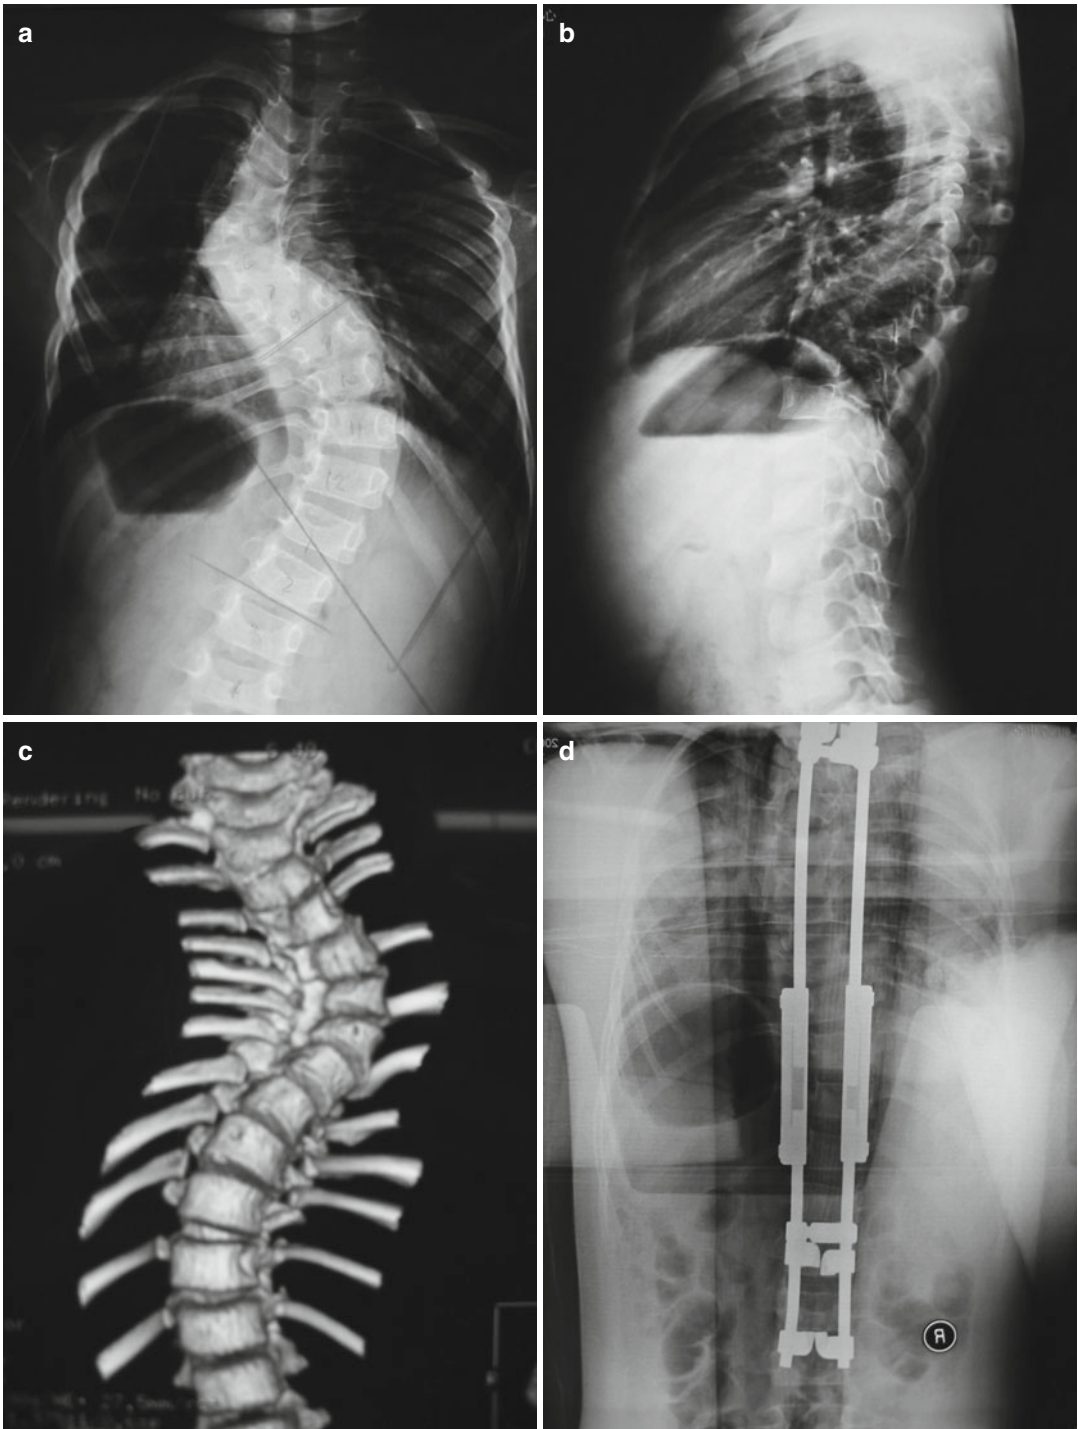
A 6-year-old female with 80° thoracic scoliosis which was untreated. Preoperative 3D CT scan and x-rays (a–c) show presence of typical radiological features of dystrophic vertebral bodies. She underwent a growing rod
